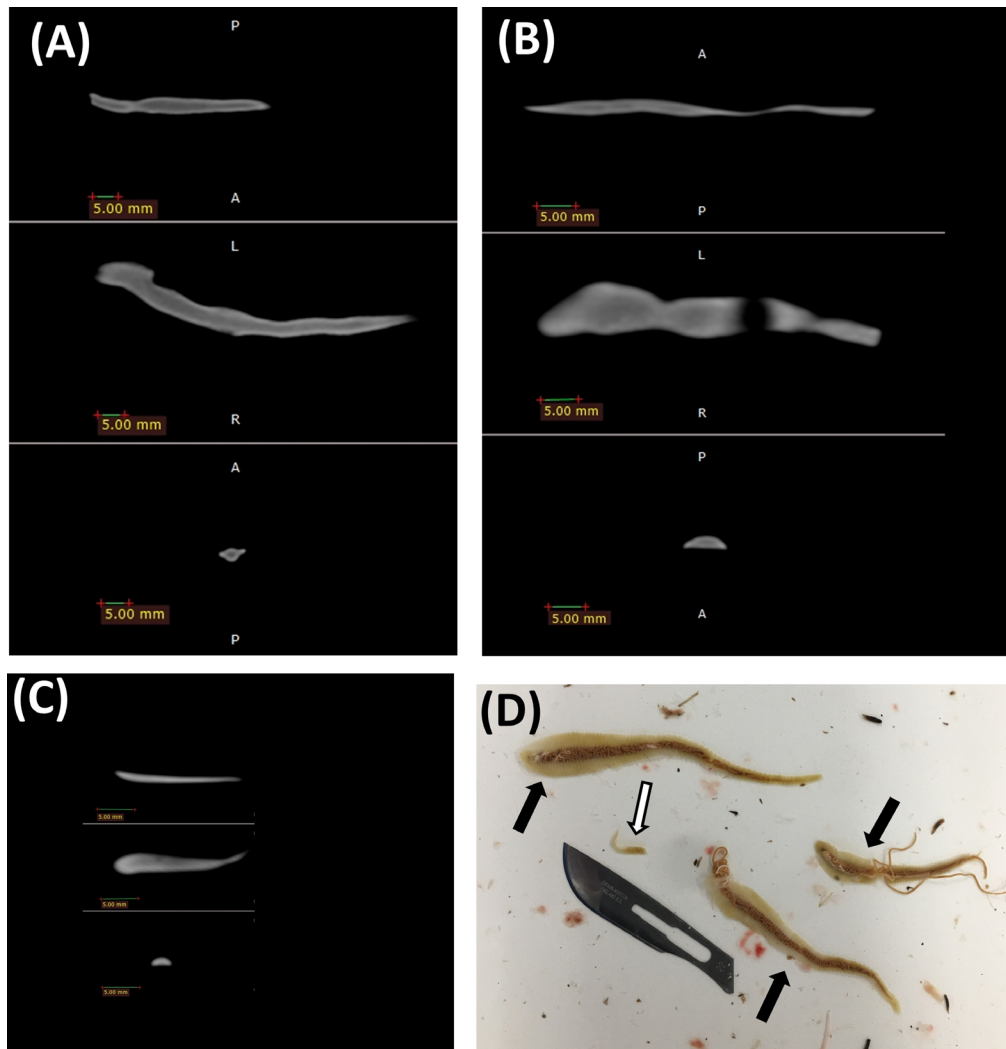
Bone window CT images of two female tongue worms (A and B) and a male tongue worm (C). Sagittal, dorsal, and transverse views are included, from top to bottom, respectively. The transverse views are obtained at the cranial third of the body. Note: Only part of the female tongue worms are visible in the sagittal and dorsal planes due to the body's undulation. D, Photograph of tongue worms retrieved at necropsy, for comparison. Black arrows, female tongue worms; white arrow, male tongue worms. A No. 22 scalpel (length = 5.5 cm) has been included for scale.
